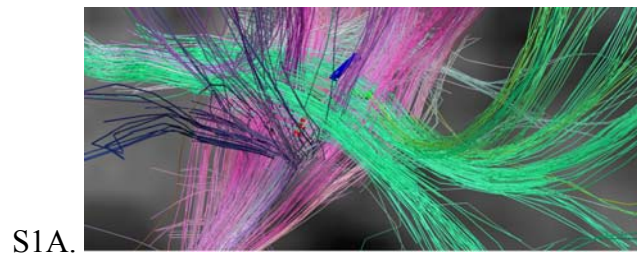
Improved detection of a known crossing of pathways due to improved diffusion resolution (smaller R_{eff}) (12). In vivo DSIs in a normal human subject with MRI acquisitions with different diffusion encoding gradient strength and diffusion resolution and scan parameters otherwise identical (TR, TE, image matrix). In this lateral
